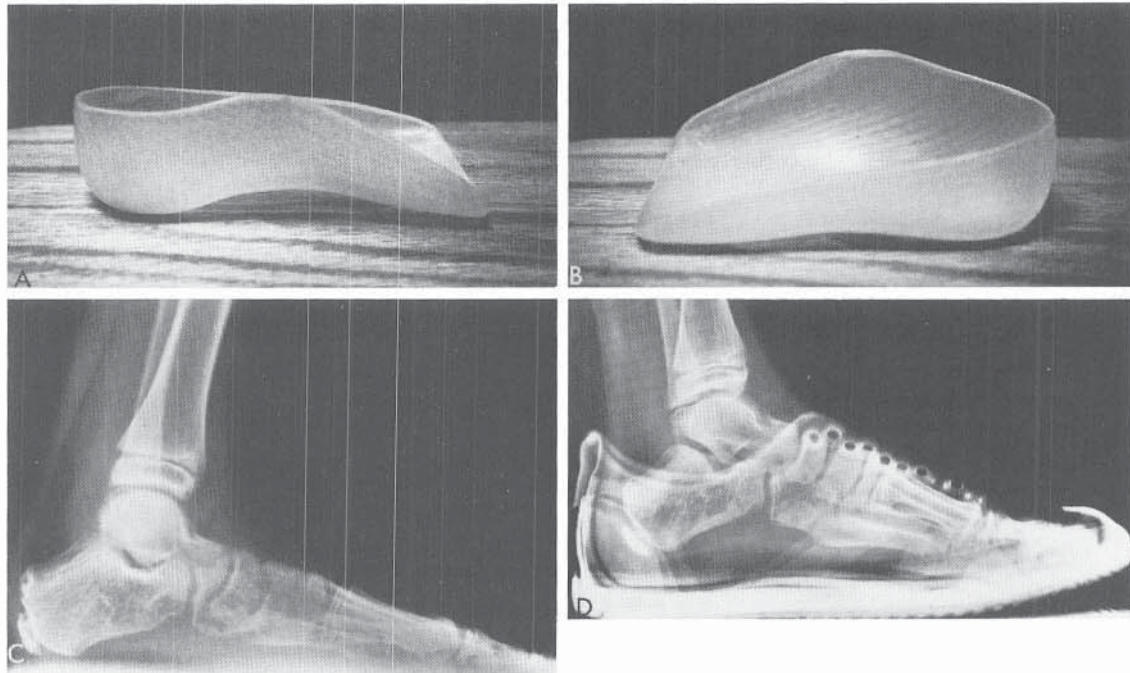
A and B, The UCBL orthosis, used in the treatment of flatfoot. C, Standing lateral radiograph showing naviculocuneiform sag. D, Standing lateral radiograph with UCBL orthosis. Naviculocuneiform sag and calcaneal dorsiflexion (“pitch”) are improved.
